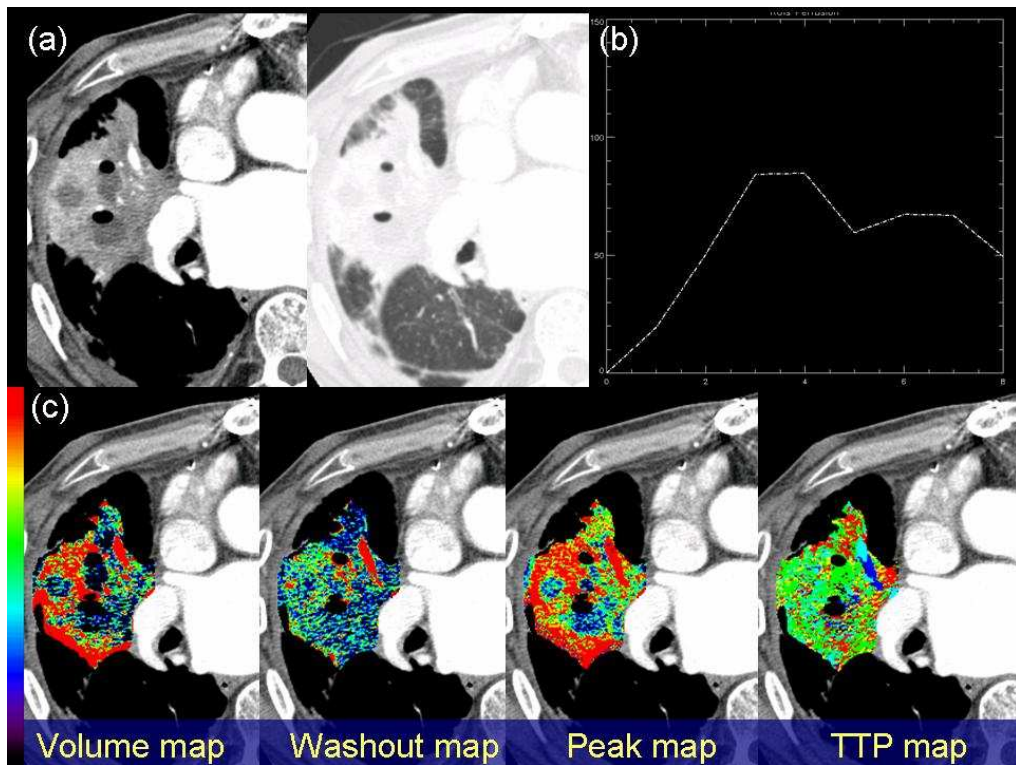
Chest CT and parametric perfusion maps in a 55-year-old man with squamous cell carcinoma in the right upper lobe.
